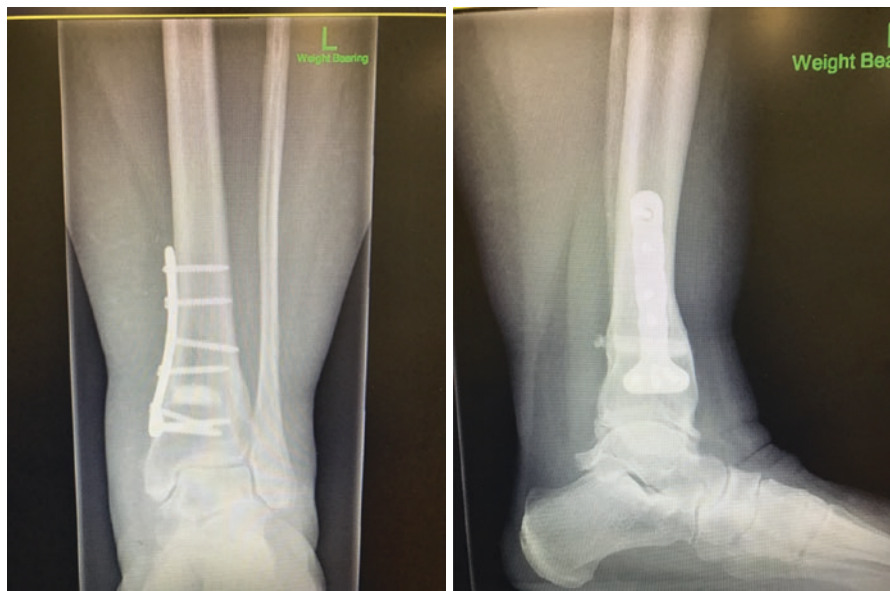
AP and lateral postoperative radiographs following horizontal distal tibial osteotomy
